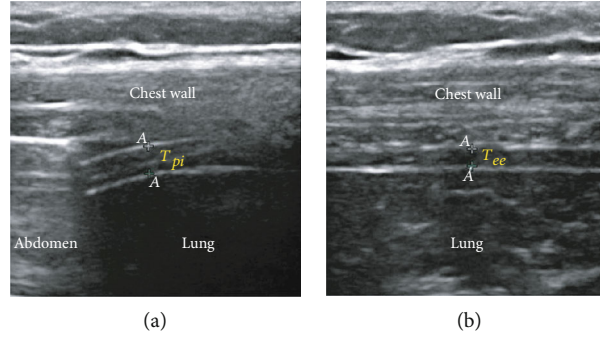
Measurement of diaphragm thickening fraction (TF) by ultrasonography. The diaphragm thicknesses at peak inspiration (T_{pi}) (a) and end expiration (T_{ee}) (b) were measured. Diaphragm TF was calculated as follows: $TF = (T_{pi} - T_{ee})/T_{ee}$.
